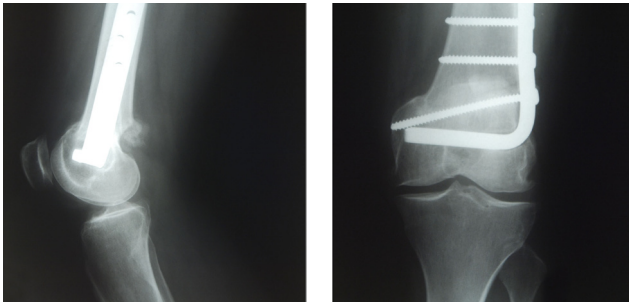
Multiple postoperative radiographs of left knee.
